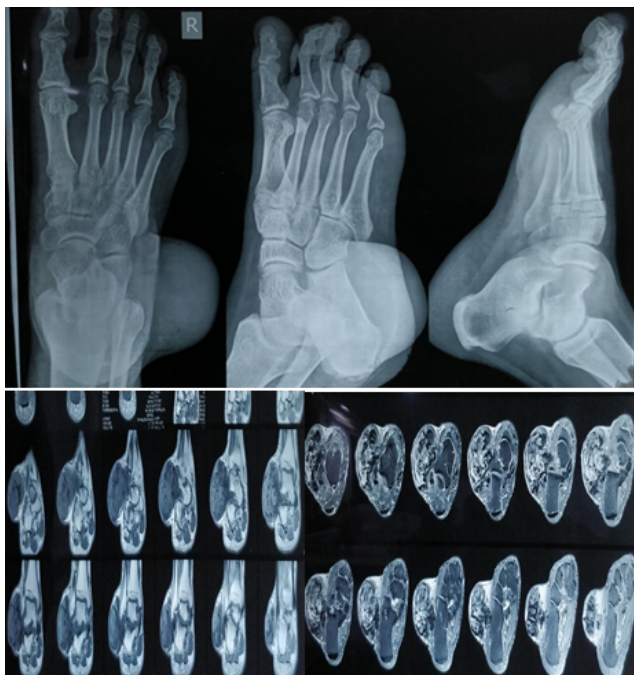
Plain radiograph of ankle showed shadow of the swelling and confirmed that the swelling was not bony
